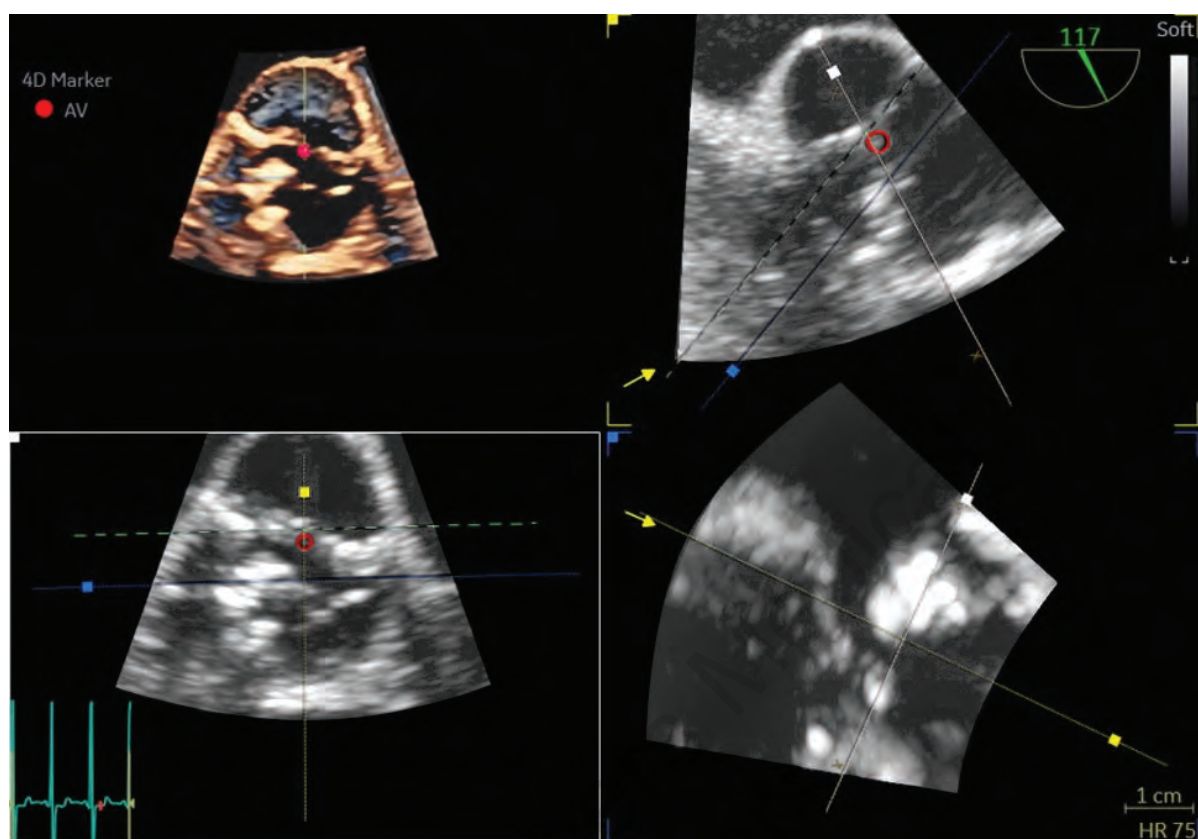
The role of three-dimensional echocardiography for proper alignment of the imaging plane at the leaflet tips for accurate measurement of aortic valve area by planimetry.
